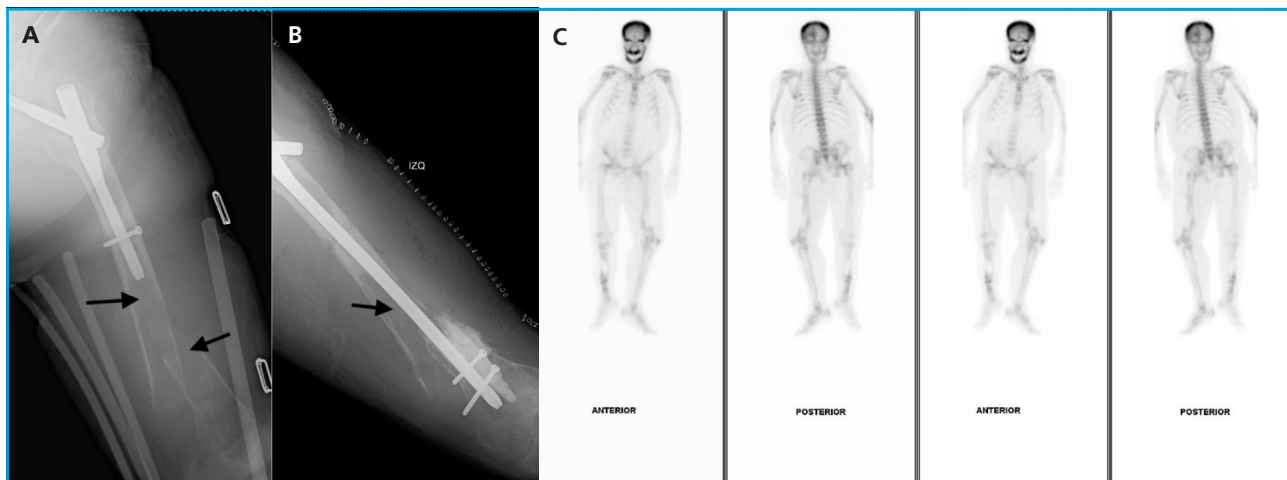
A. Plain X-ray of the left femur in an anteroposterior projection showing a diaphyseal fracture and osteolytic lesions at the fracture site. B. Plain X-ray of the postoperative femur. C. Bone scan performed with technetium showing hypercaptation in the skull, jaw, axial, and appendicular skeleton.
